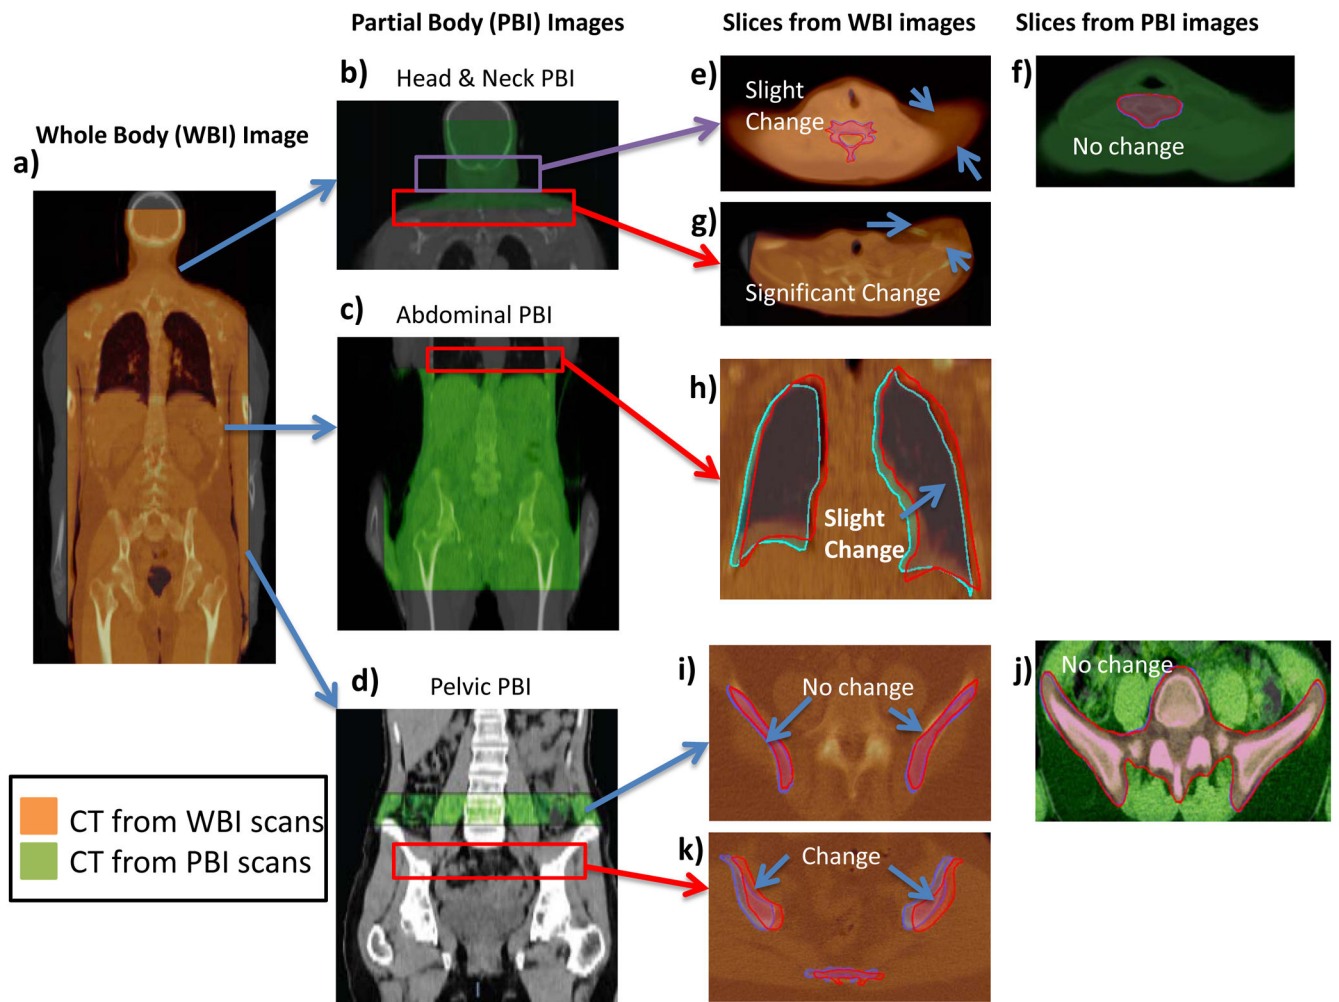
Examples of WBI and PBI and their respective registrations. (a) Whole Body registration with associated kVCT. Three sub-regions commonly imaged in PBI: (b) head and neck. (c) abdominal, and (d) pelvic are shown registering with their kVCTs. Red boxes indicate regions where PBI was not performed but significant mismatches in WBI were found. Slices from WBI and PBI are shown for various regions (e–k). Orange CT scans are from WBI scans. Green CT scans are from PBI scans. Regions outside of PBI imaging show mismatch in WBI while only slight mismatches occur in nearby PBI images regions.
